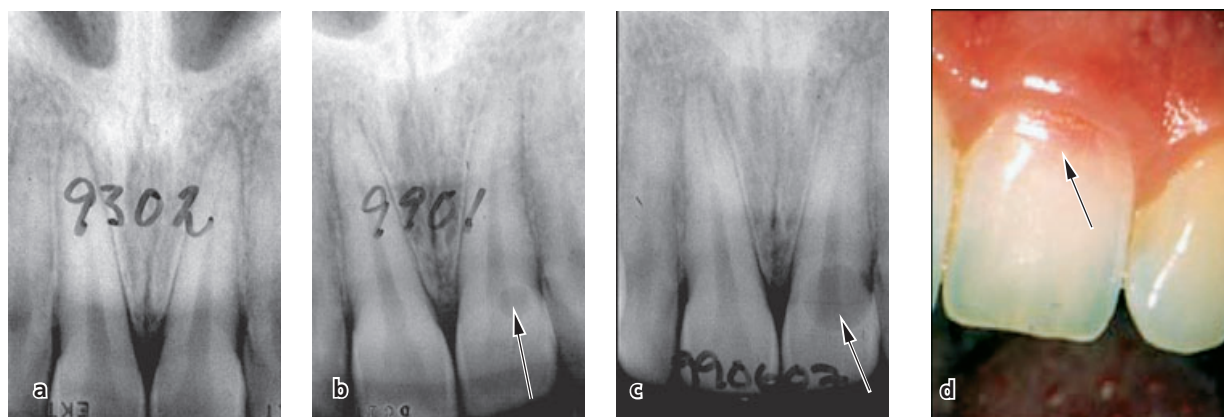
Series of radiographs taken at different time intervals showing the appearance of an external root resorption in a young adult patient. (a) At the age of 15 years there is no sign of resorption. (b) Six years later a small radiolucency is seen (arrow). (c) In just 6 months the lesion expanded considerably (arrow). (d) The lesion appeared clinically as a pink spot in the cervical area of the tooth (arrow). Case kindly provided by Dr. Anders Molander.
